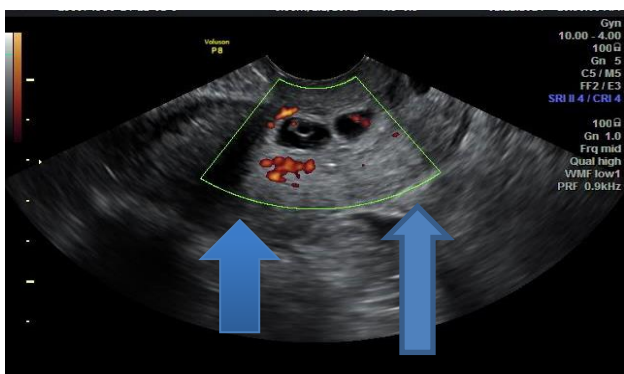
Doppler ultrasound showing peritrophoblastic flow (blue arrows).
